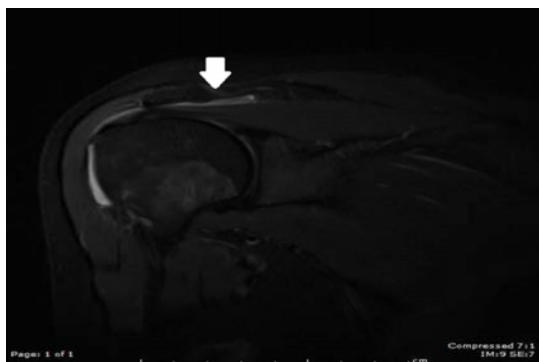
Coronal STIR MRI scan of the right shoulder shows subacromial-subdeltoid bursitis manifested by abnormal collection of fluid deep to the acromion and deltoid muscle (white arrow)
